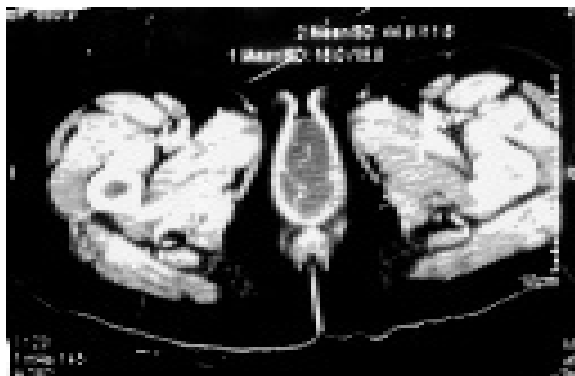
Transverse CT scan showing the cysts.
